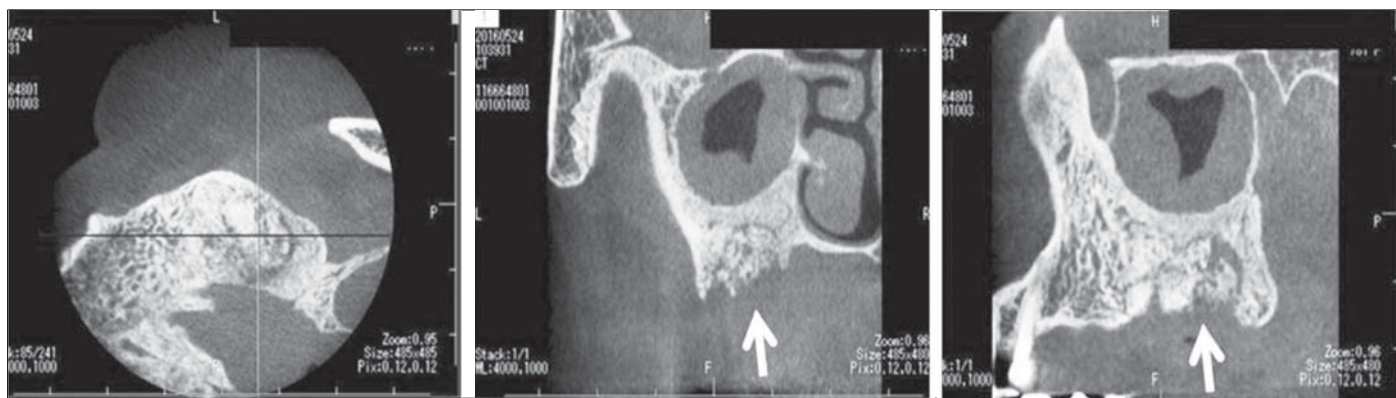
Dental cone beam computed tomography shows sequestrum (white arrow) in a BRONJ patient. (Reprinted with permission from Taguchi et al¹⁷).
